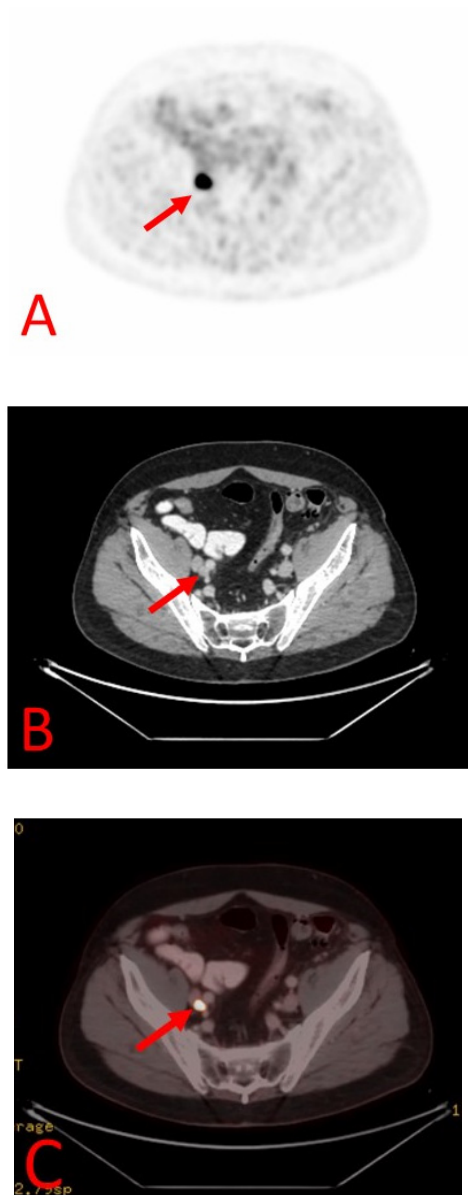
[^{18}F]PSMA-1007 PET-CT.
